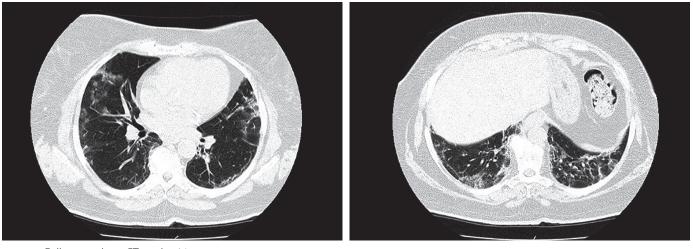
Follow-up chest-CT on day 14.
